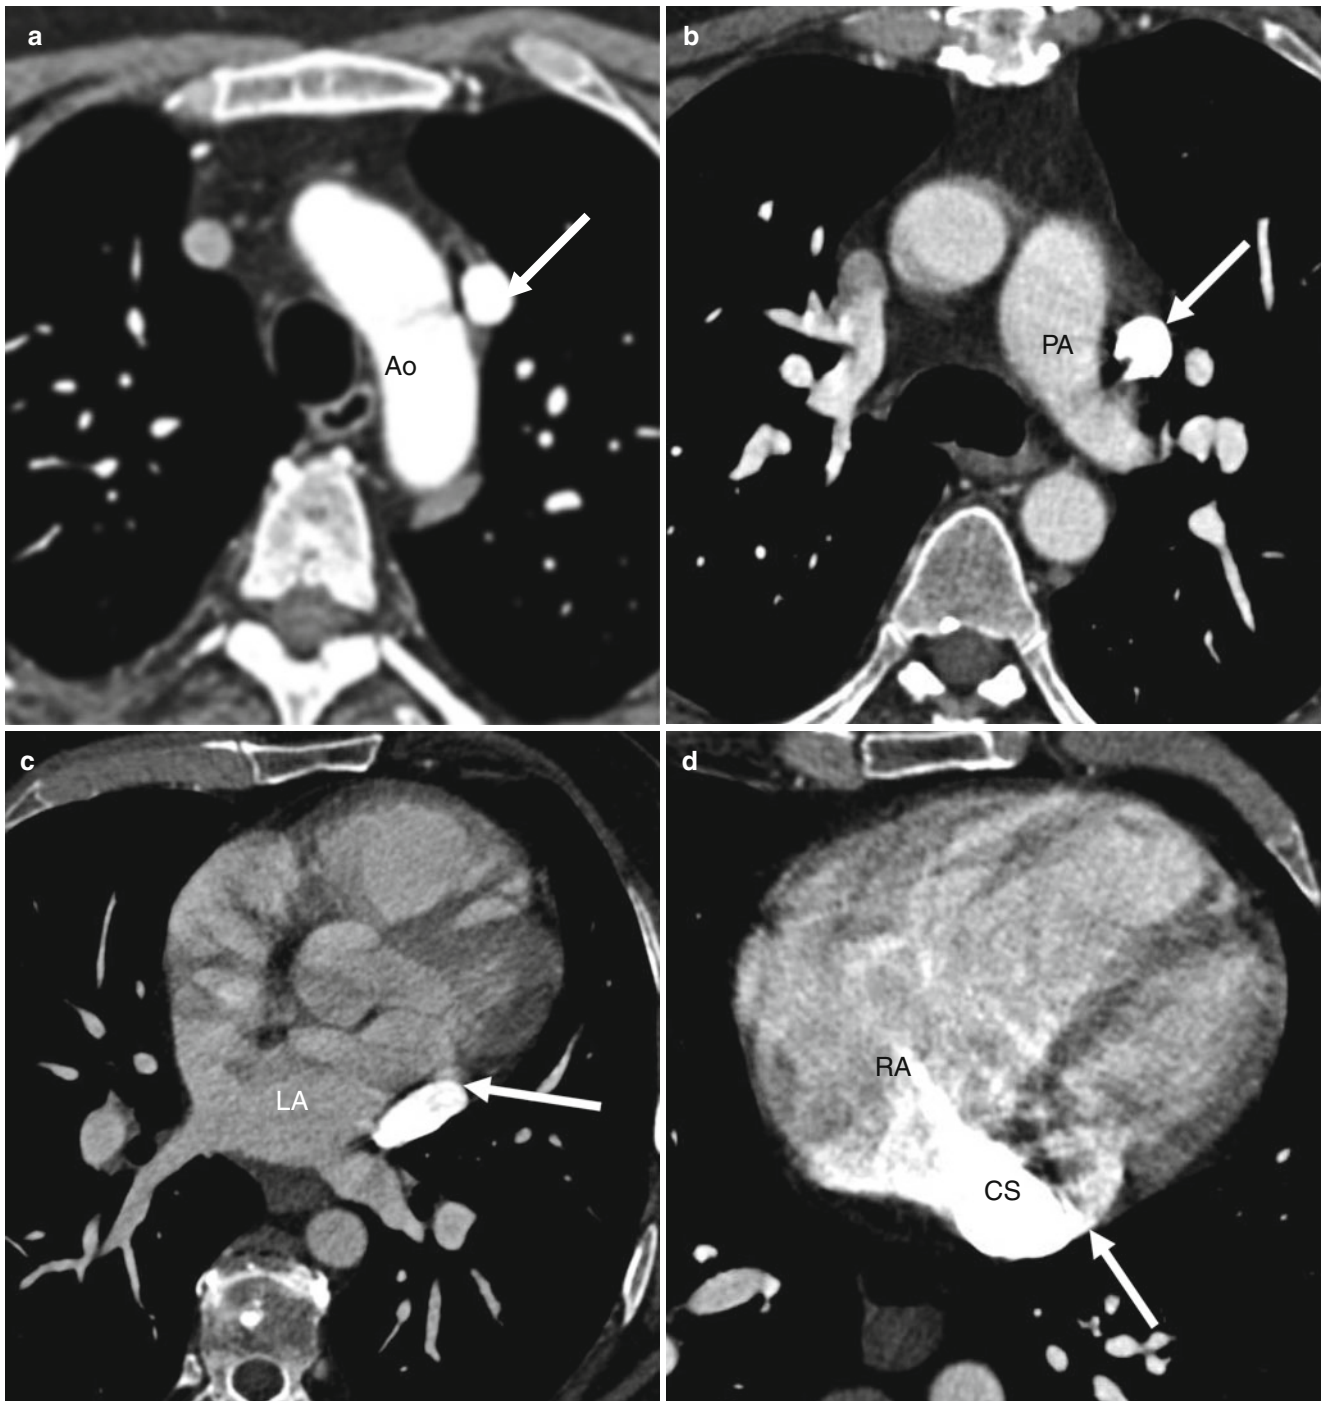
Persistent left superior vena cava (LSVC). Here, multiple axial CT images show the course of the LSVC as it travels to the coronary sinus. In panel (a) note the vessel lateral to the aortic arch (Ao) as the persistent LSVC (arrow). In panel (b) the LSVC (arrow) courses lateral toward the pulmonary artery (PA). In panel (c) the LSVC (arrow) is seen
